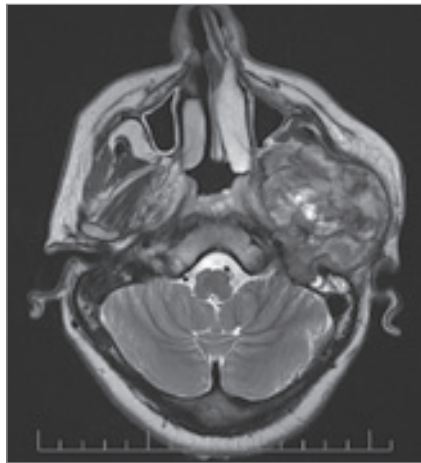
Pre-operative MRI – first case.
